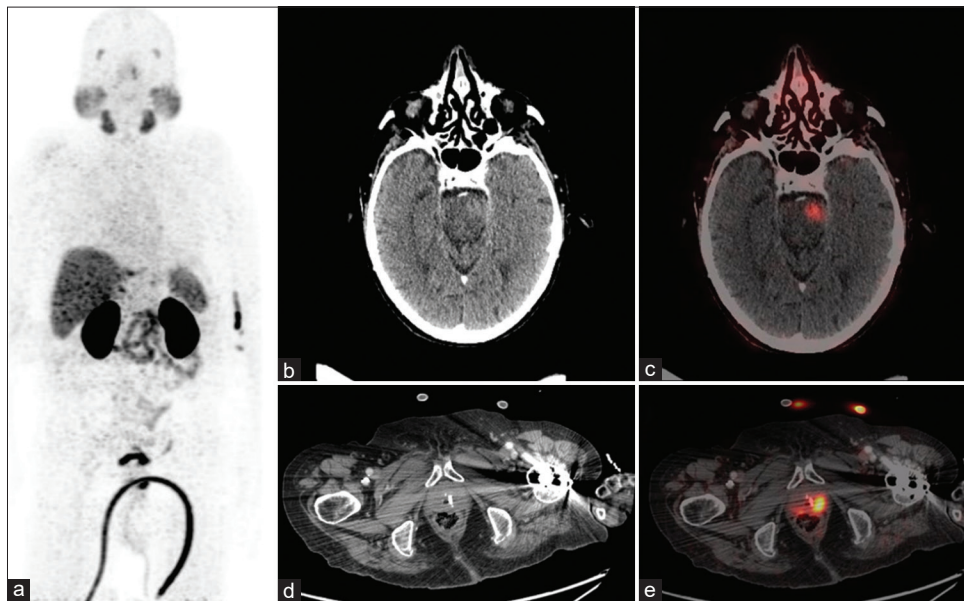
Maximum intensity projection images (a), axial computed tomography (CT) (b and d) and axial fused positron emission tomography/CT (d and e) sections of 68Ga-prostate specific membrane antigen (PSMA) PET/CT. Scan shows heterogeneously enhancing foci with increased FDG uptake in brain stem involving mid brain (white arrow image c, SUVmax-7.3) and pons. Note is made of focal PSMA avid lesion in left lobe of prostate gland (thick white arrow image e, SUVmax-19.1)
